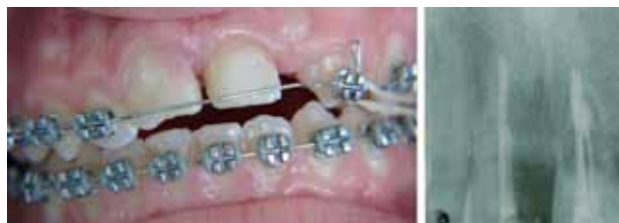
Clinical image and radiograph of an infraoccluded upper central incisors showing ankylosis and advanced root resorption.
